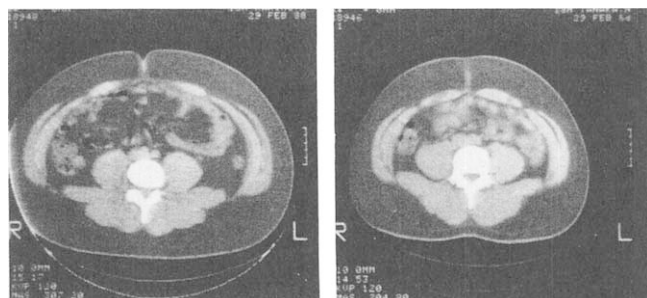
CT scan of types of fat distribution at umbilical level of two obese women.
